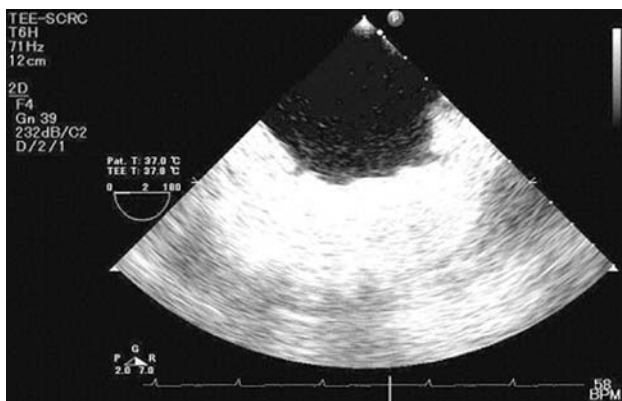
Hypoechoic space in the stomach revealed by transesophageal echocardiography (TEE)
